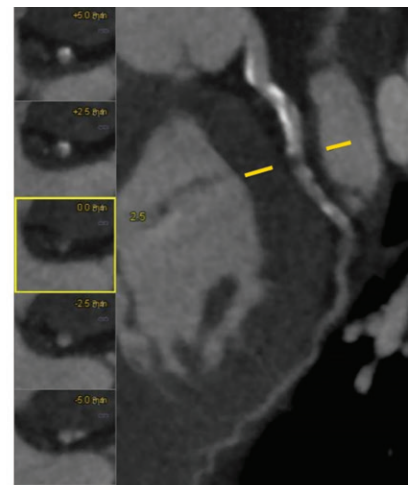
CAD-RADS 3 in a 65-year-old man with atypical chest pain. Curved MPR CT angiographic image (left) and corresponding axial CT images (right) show a noncalcified plaque (arrows) at the mid LAD artery that is causing moderate stenosis (50%–69%). Functional assessment was recommended. Myocardial perfusion scintigraphy (not shown) showed a stress perfusion defect in the apical anterior and inferior segments, which is consistent with ischemia.
